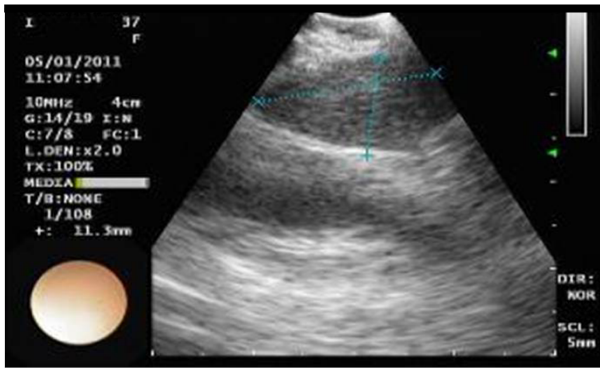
An endobronchial ultrasound image of anthracotic lymph node with distinct margin and homogeneous echogenicity in the right paratracheal area.
